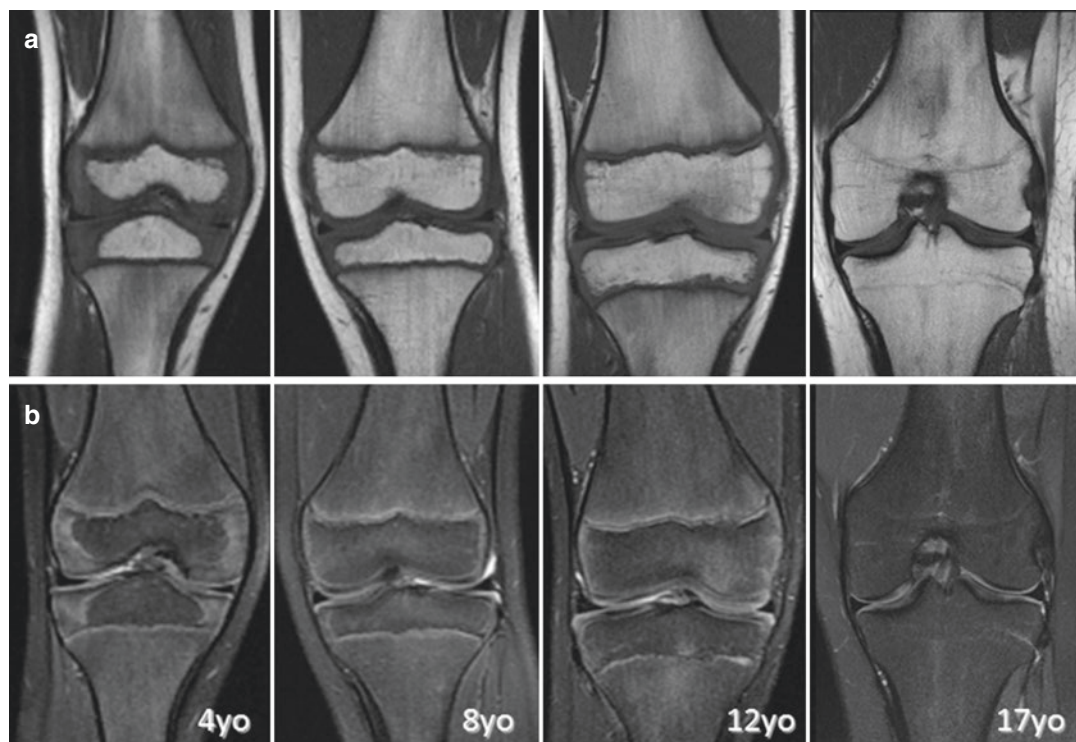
Coronal T1 (a) and T2 fat sat (b) weighted of normal MRI views of the knee in young patients aged 4, 8, 12, and 17 years old
